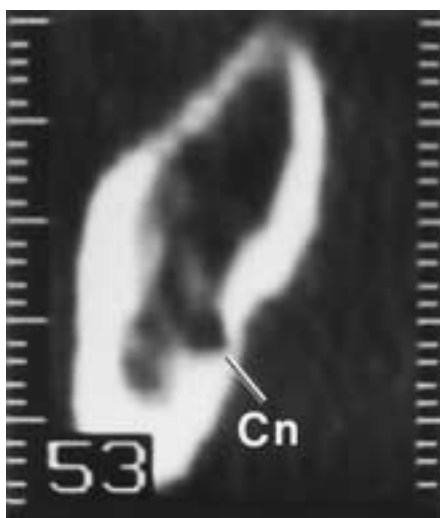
Cortical niche sign. This cross-sectional image of the mandible demonstrates an indentation on the lingual cortex of the mandible called the cortical niche sign (Cn), which is created by the mandibular nerve as it traverses the mandible. This sign, which is often more subtle than this, can be helpful in identifying the location of the mandibular canal. (From Abrahams JJ. CT assessment of dental implant planning. *Oral Maxillofac Surg Clin North Am* 1992;4:1–18.)
